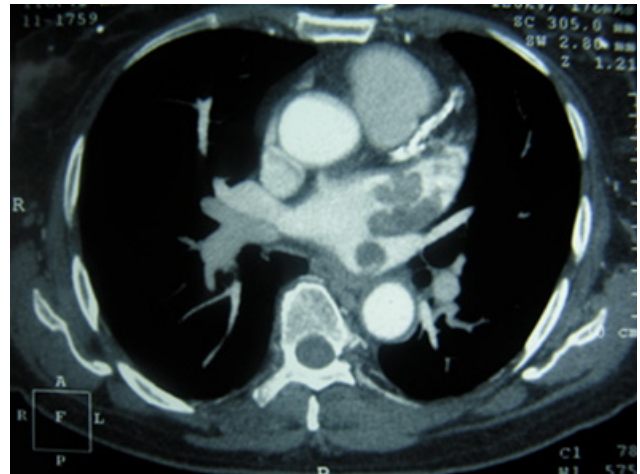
Cardiac CT scan of 68/F with left atrial masses. The masses is at the left atrial appendage, extending into the left atrial cavity.
